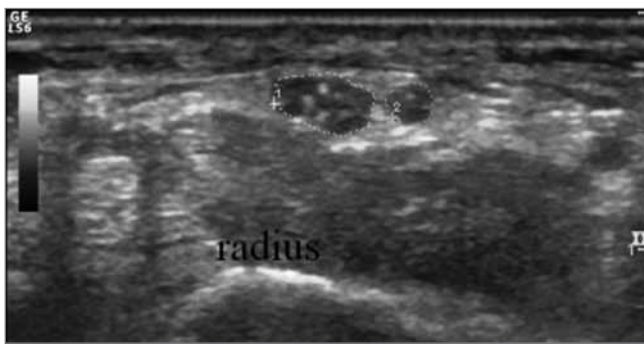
Axial ultrasound image of the circled median nerve in right wrist; two branches of the median nerve at the level of radiocarpal joint; the echogenic line indicates the head of the radius.
